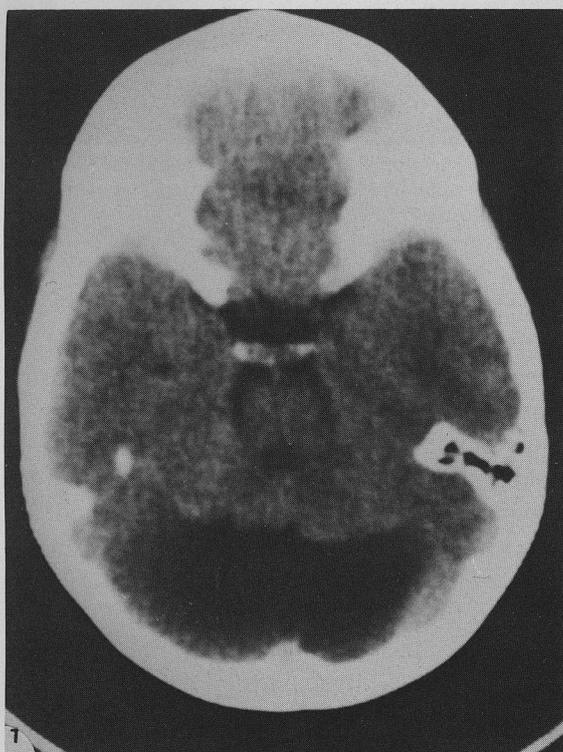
Hypoplasia of cerebellar vermis and hemispheres, enlarged cisterna magna. CT, axial section, case 1.
